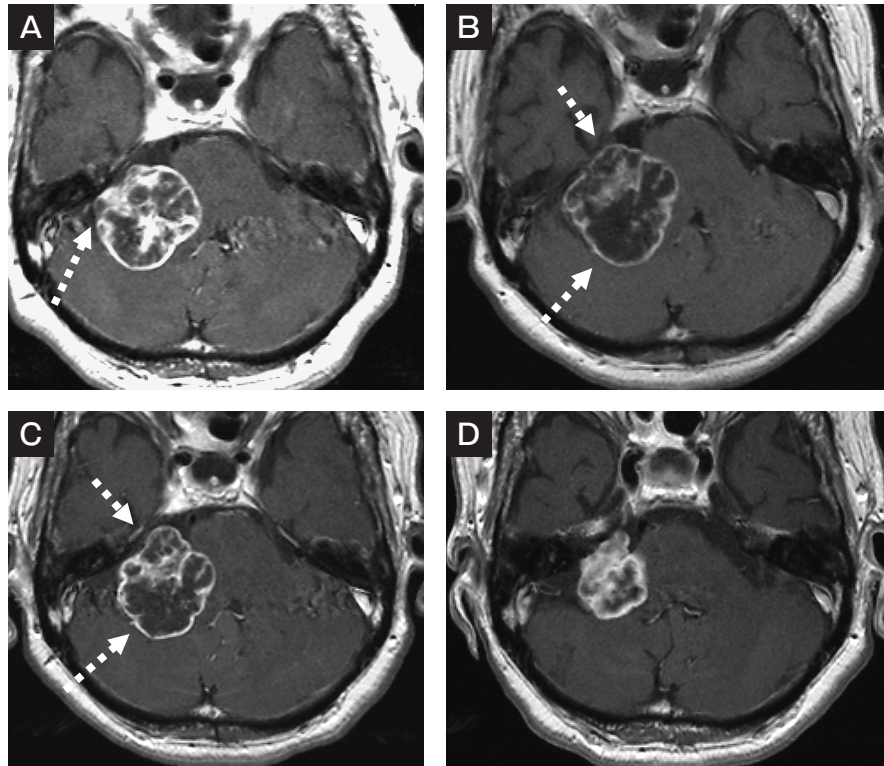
Axial views of gadolinium-enhanced MRI: A, prior to Gamma Knife radiosurgery (GKS). The arrowheads demonstrate a small space in the cerebellopontine cistern; B, Six months after GKS. The anterior (upper arrowhead) and posterior part (lower arrowhead) of the tumor show enlargement; C, Twelve months after GKS. Protrusion of the anterior part (upper arrowhead) remained; however, the right lateral part (lower arrowhead) of the tumor had shrunk; D, Thirty-seven months after GKS. The volume of the tumor had completely shrunk.
